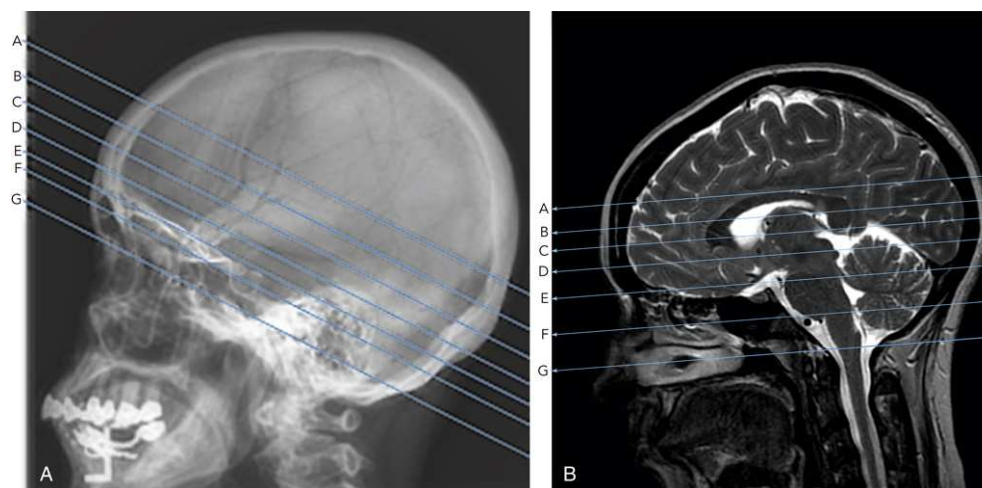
(A) CT localizer (scout) image of skull. (B) Sagittal localizer for MRI of the brain.
